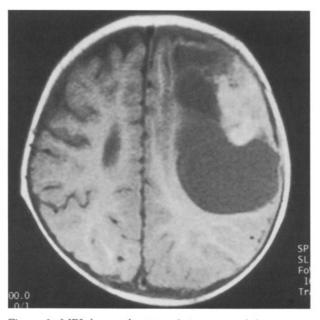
MRI shows a large cystic mass containing septae.
